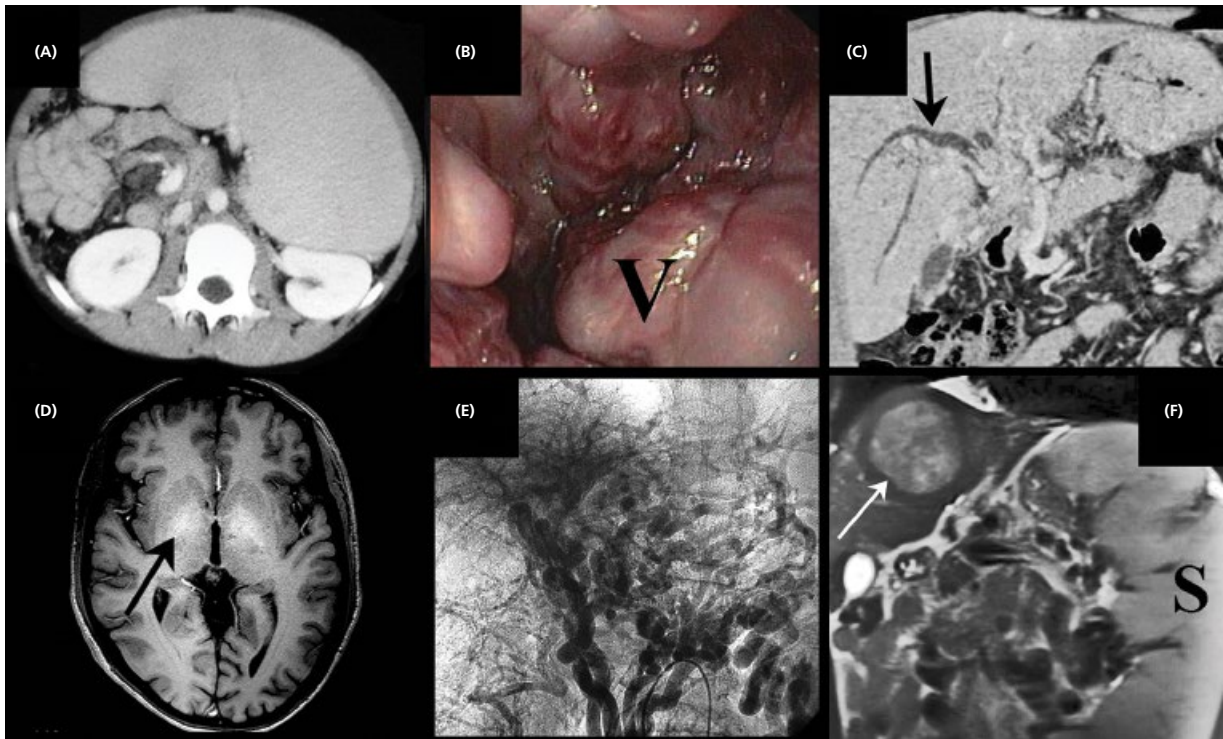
Complications of portal hypertension. (A) Splenomegaly. (B) Esophageal varices. V indicates a large, grade III varice. (C) Portal biliopathy in patients with portal cavernoma (arrow shows a dilate intrahepatic bile duct). (D) MRI T1-GRE hyperintense signal in globus pallidus (arrow) suggesting chronic encephalopathy. (E) Complete splanchnic vein system thrombosis. (F) Liver parenchymal atrophy and growth of regeneration node (arrow) in a patient with portal cavernoma and massive splenomegaly (S).
